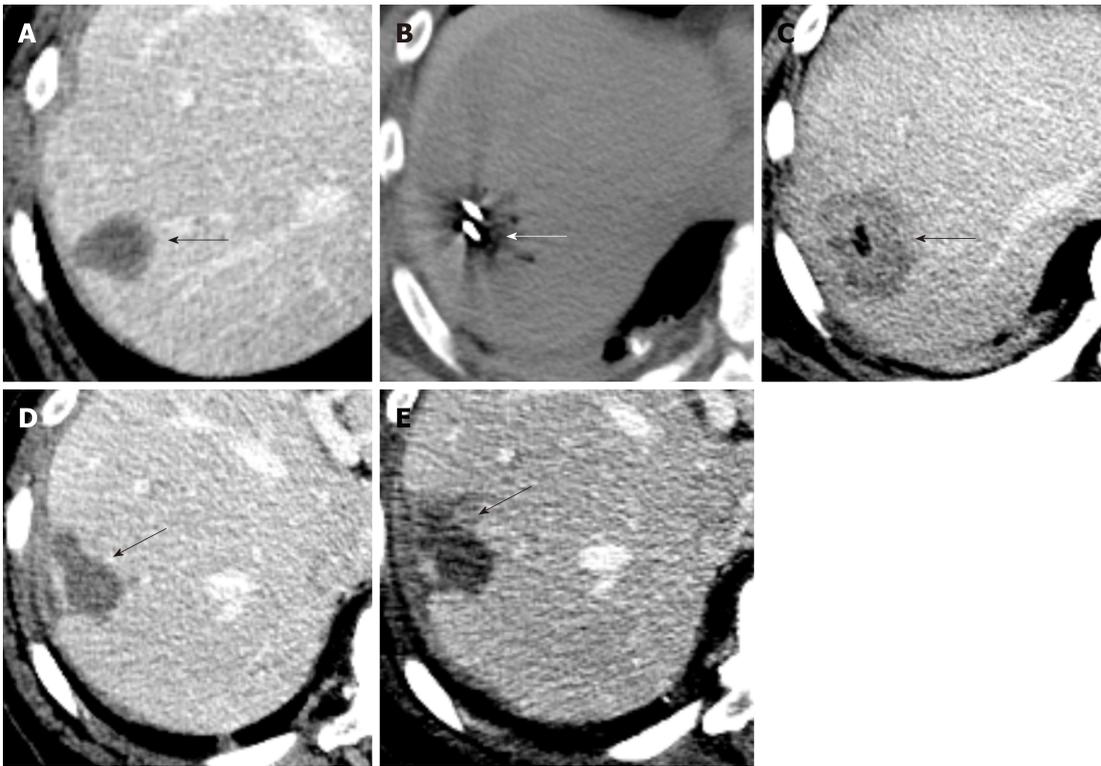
Ablation of hepatic hemangioepithelioma. A: Axial contrast enhanced CT image shows a 3 cm hepatic hemangioepithelioma nodule (arrow) in segment 7 of the liver; B: Axial non-contrast CT image shows microwave ablation of liver of the segment 7 nodule (arrow); C: Immediate post ablation axial contrast enhanced CT image shows an ablation cavity (arrow); D: Follow up axial contrast CT image after 3 mo and; E: Axial contrast CT image 6 mo show an evolving post ablation cavity and tract (arrow).
